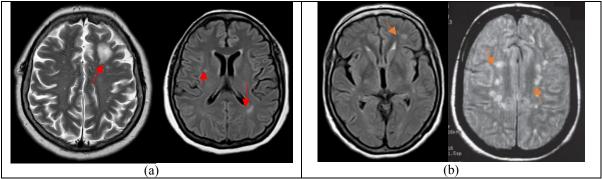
MRI images of (a) Ischemia brain disease (BI) and (b) Demyelinating disease (BD); before the processing.
